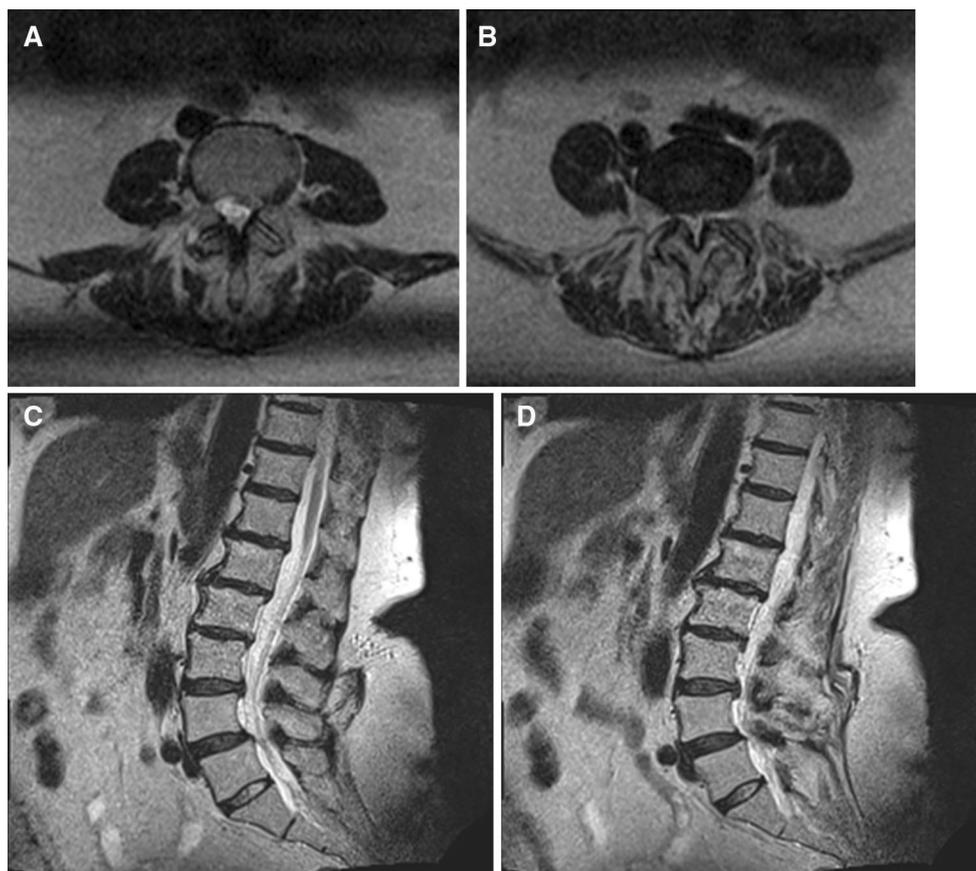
T2 weighted MRI images: a L3–L4 level; b L4–L5 level; c, d sagittal view
